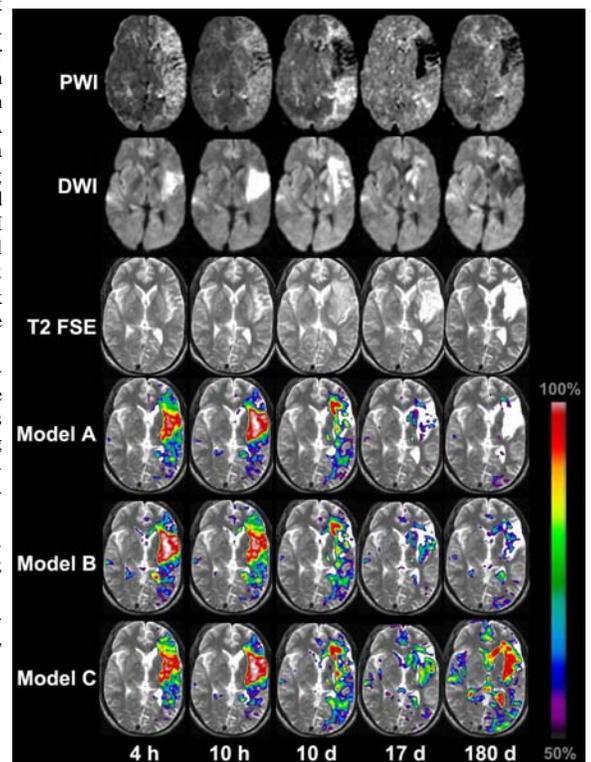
Examples of predicted risk of infarction over time using three different models along with DWI/PWI and T2 FSE data. The model which incorporates temporal information (Model C) provides over a wide range of times the best prediction of final infarct volume (T2 FSE at 180 d).
